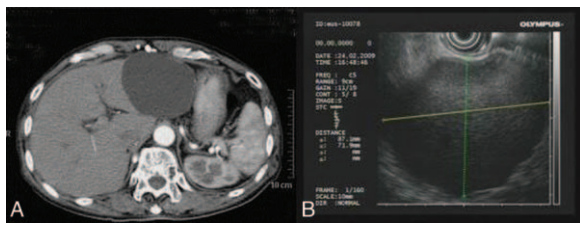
Preparation CT (A); preparation EUS (B).
